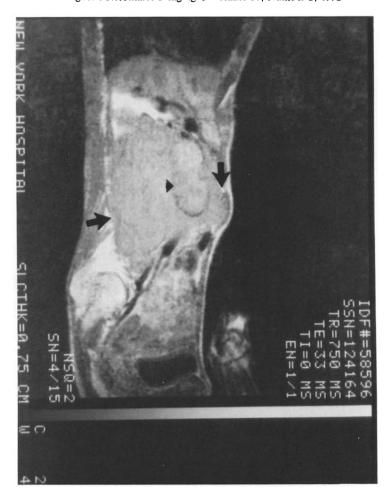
SE 650/33 sagittal MR image demonstrates the mass extending to the anterior abdominal wall (arrows), and the old pseudoaneurysm with calcified rim (arrowhead).
